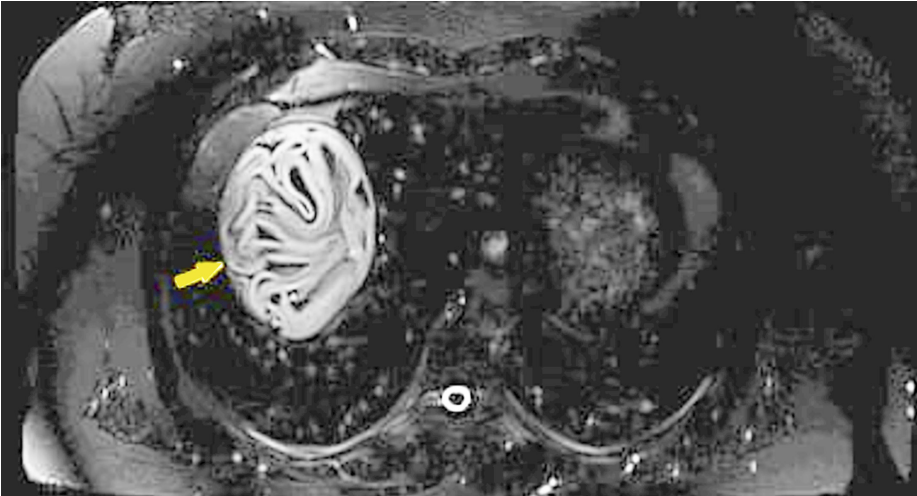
Magnetic resonance imaging of liver hydatid cyst at first cholangitis attack (shown by a yellow arrow).
